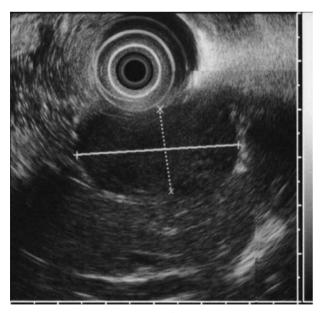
Endoscopy ultrasound of submucosal hypoechoic mass in the 4<sup>th</sup> EUS layer.
